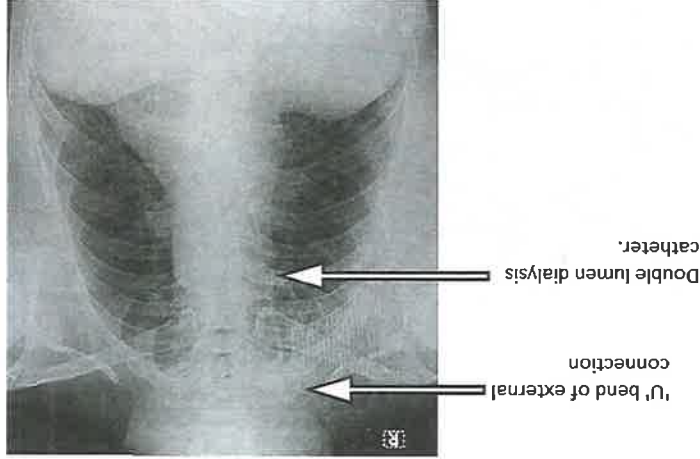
X-ray chest showing temporary (non-cuffed) double lumen hemodialysis catheter introduced through right internal jugular vein.
